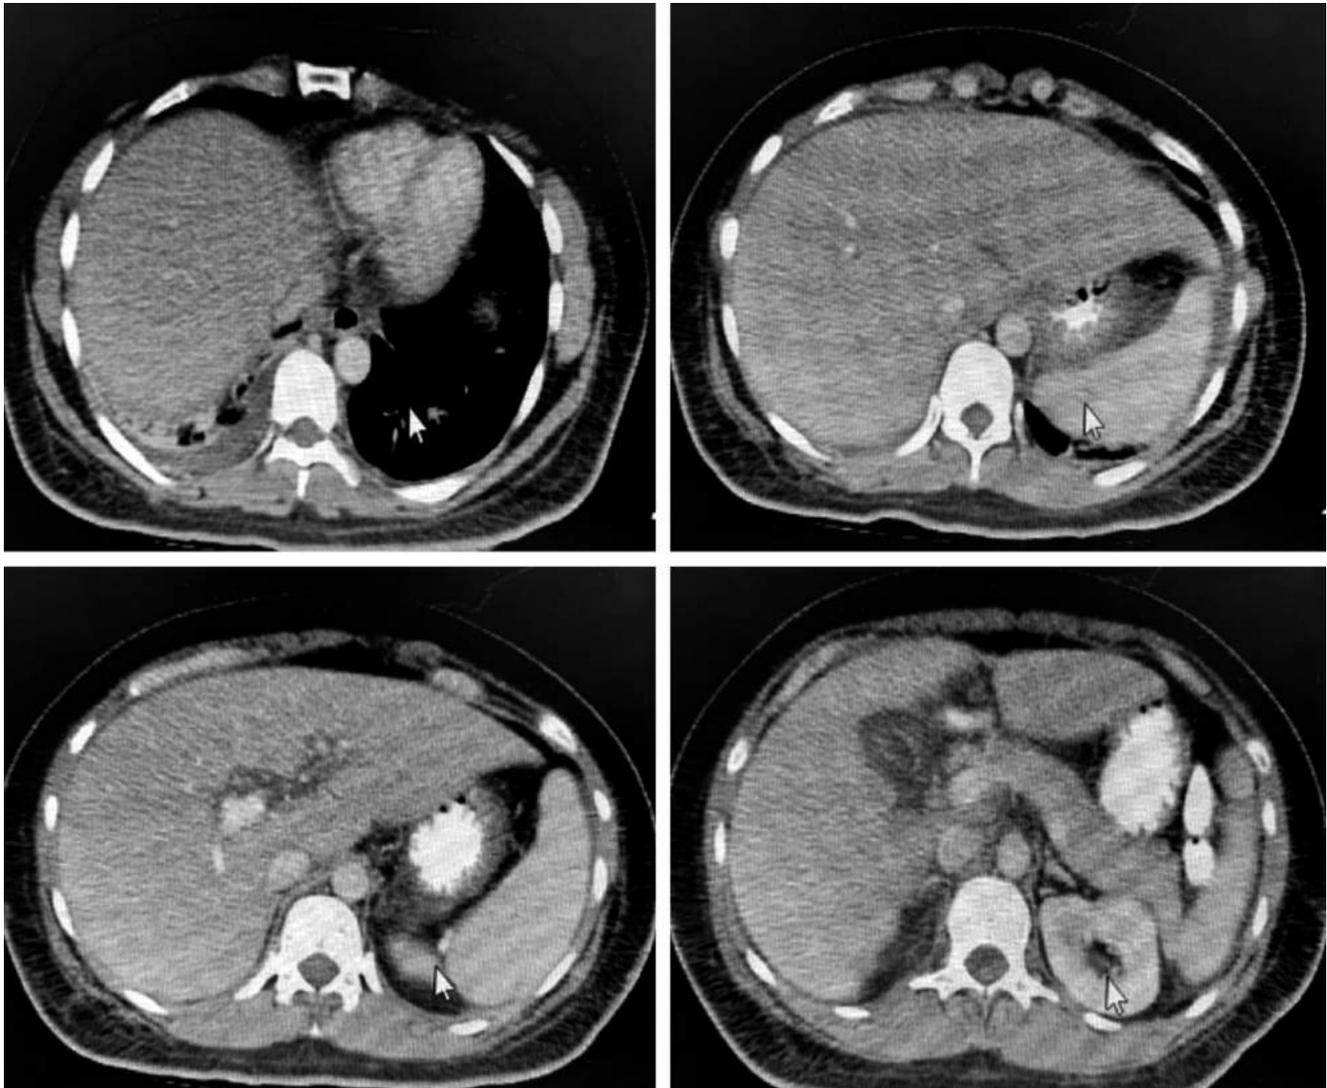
Computed tomography (CT) scan of the patient's abdomen. Right laminar pleural effusion with subsegmental atelectasis. Diffuse hepatic steatosis without focal lesions. Findings described at the pancreatic level suggest interstitial edematous process Balthazar C. Severity index 2. Right renal hypodense nodular image compatible with a cyst. Intra-abdominal laminar fluid. Courtesy of HUDN Radiology Department
